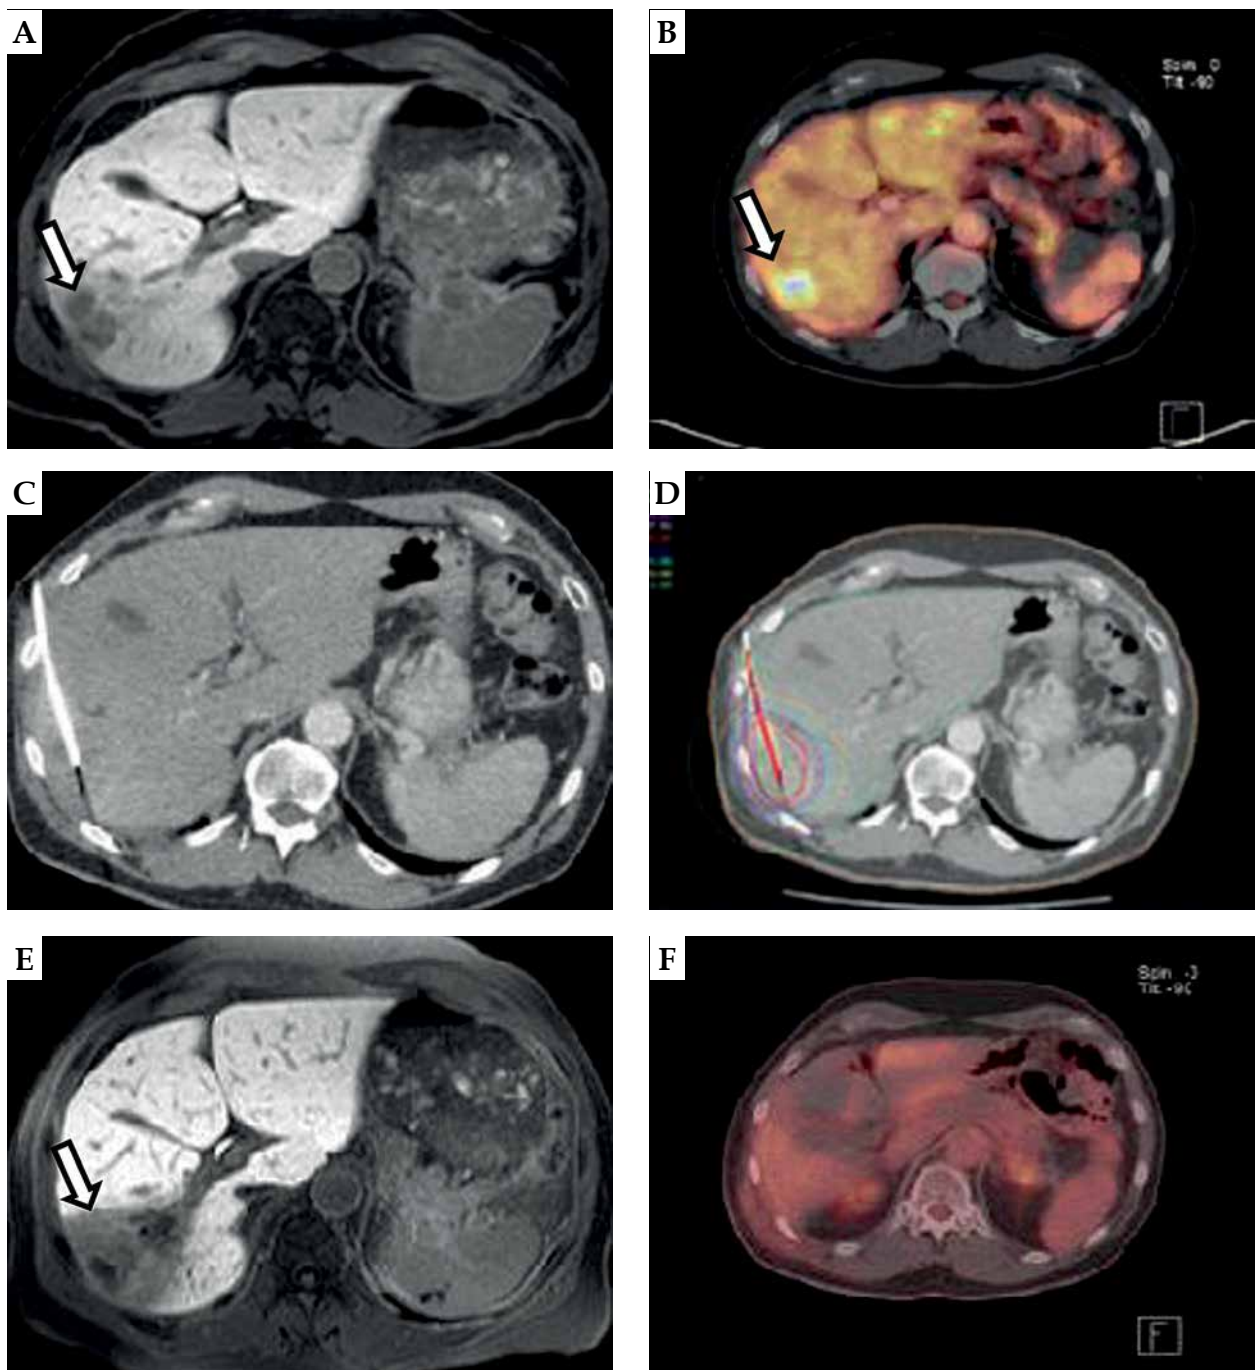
Local tumor control in a patient with metastatic PDAC. A) Axial T1w Gd-EOB-DTPA (Primovist)-enhanced MRI (baseline MRI prior to iBT), arrow points to liver metastases; B) FDG-PET-CT demonstrates the activity of the hepatic lesions (arrow) prior to iBT; C) Inserted brachytherapy catheter in the liver lesions (white arrow) during CT-guided iBT; D) Colored lines represent the irradiation isodoses, with red line showing 20 Gy; E) Axial T1w Gd-EOB-DTPA-enhanced follow-up MRI after iBT with Gd-EOB-DTPA enhancement defect following irradiation; F) FDG-PET-CT (follow-up) shows no activity in the hepatic ablation area
